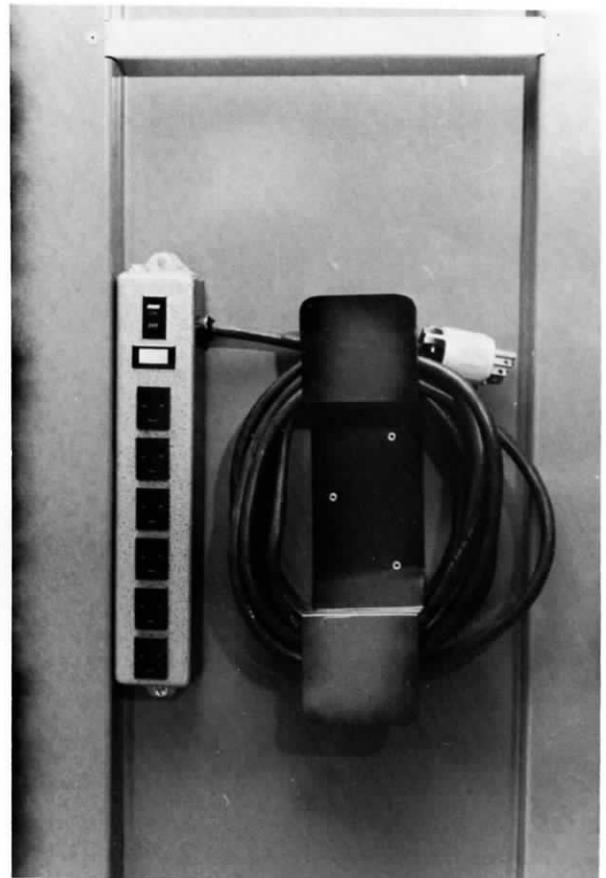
Multiple outlet box. Since most radiographic rooms do not have sufficient outlets to support all of the test gear, and to make set-up easier and quicker, a multiple outlet box with a switch and circuit breaker is mounted on the right side of the cart (relative to Figure 2.6b). In addition, an extra-long electrical cord is provided so that the cart can be positioned anywhere in the x-ray room.
